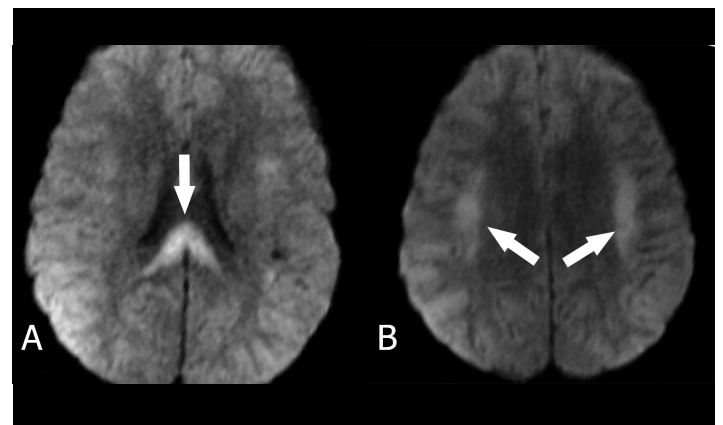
Diffusion-weighted magnetic resonance imaging demonstrated restricted diffusion on (A) splenium of the corpus callosum and (B) bilateral subcortical areas (arrows).
